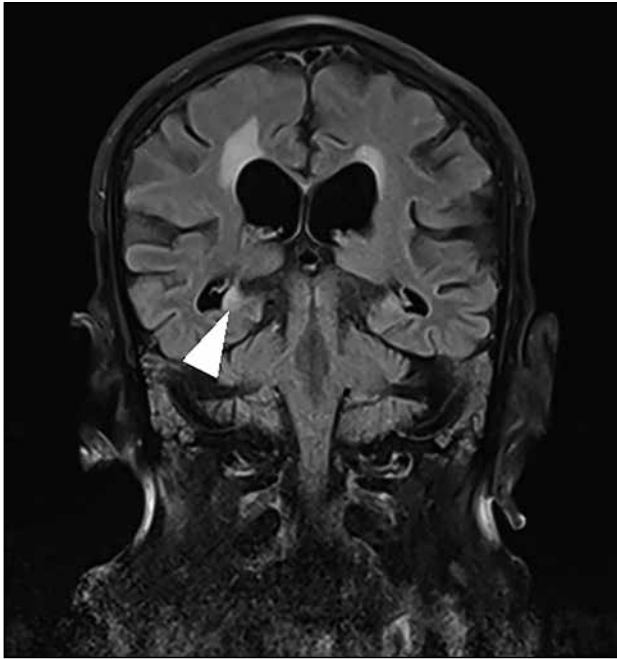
Magnetic resonance imaging of the brain 1 month after admission. The increased fluid-attenuated inversion recovery signal at the right hippocampus had become slightly more conspicuous (arrowhead).
